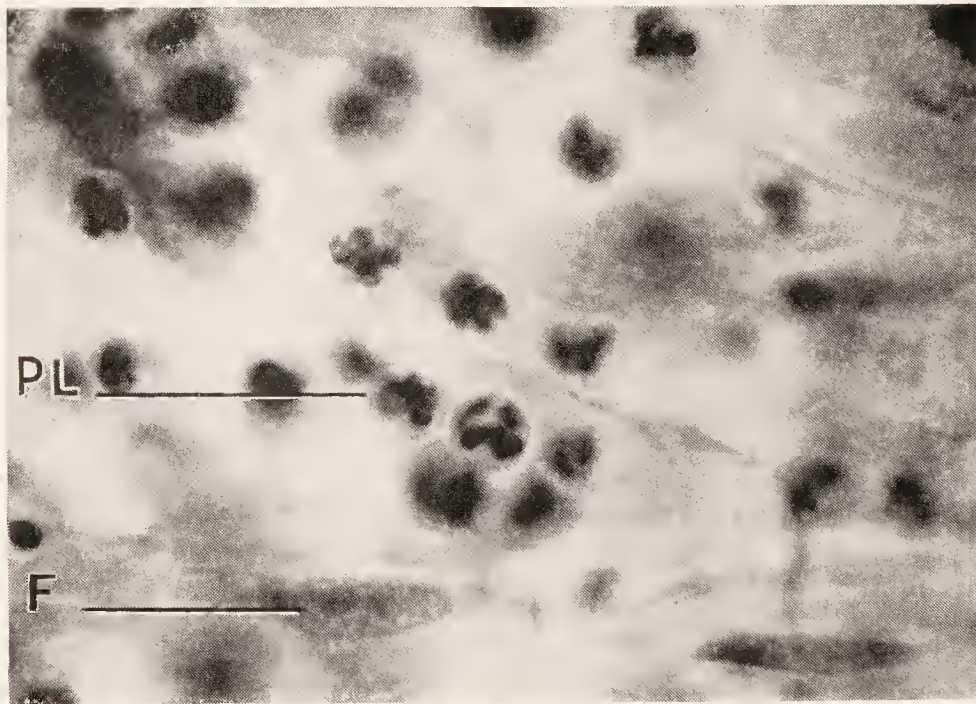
Typical cell forms in case of acute purulent inflammation of the periapical tissue. Infiltration of the connective tissue with polymorphonuclear leukocytes, PL, with round protoplasmic bodies and lobular nuclei (see also Fig. 91). F, fibroblast.
